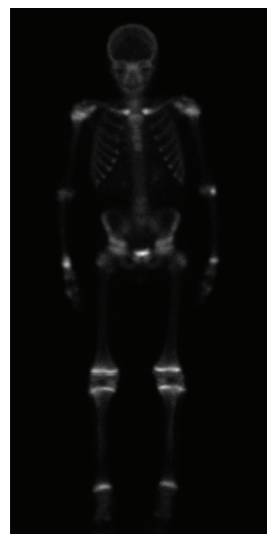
Bone gallium/scintigraphy demonstrated hypercapitation at the clavicles bilaterally as well as hypercapitation at the lateral side of the right trochanter.
